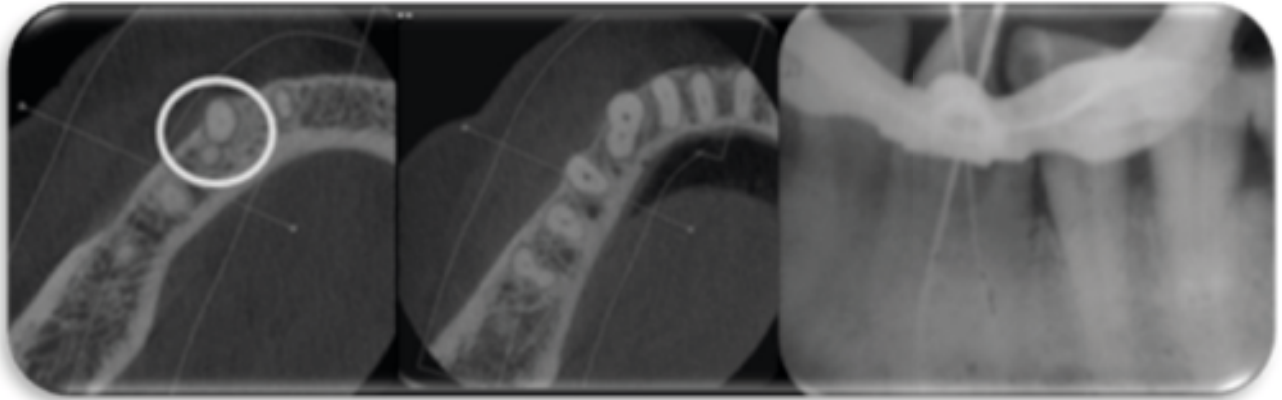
Working length & CBCT .
